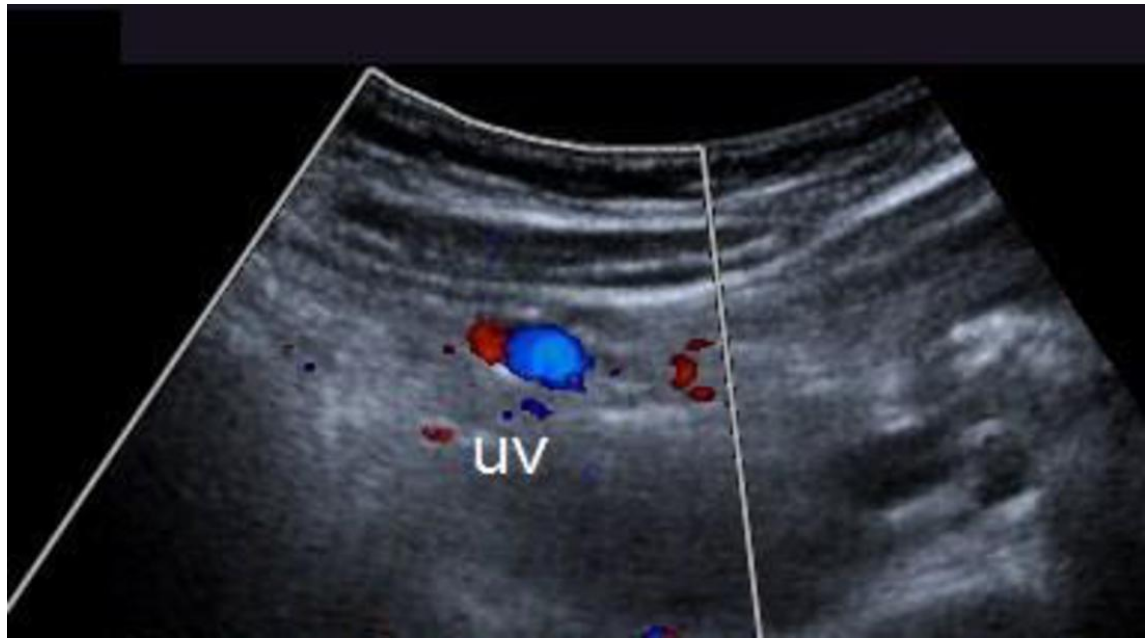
Color Doppler showing a patent umbilical vein.
